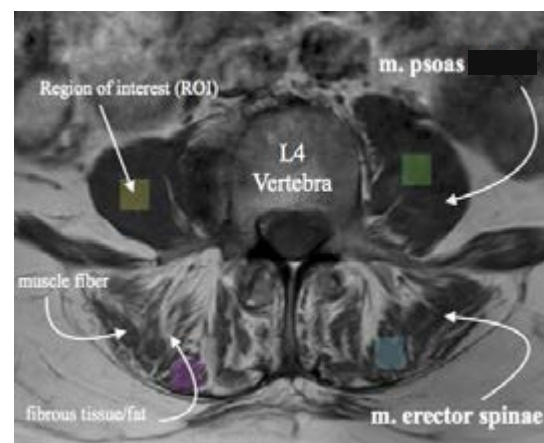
Axial view of MRI at L4. Four regions of interest (ROI) were placed bilaterally on the psoas and erector spinae to represent the regions with the least amount of fatty infiltration (black region), compared to region with fatty infiltration (white region) to differentiate these two regions in the muscles.
